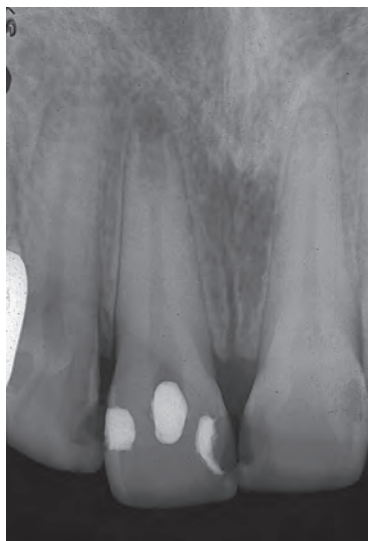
Apical inflammatory resorption has destroyed the “apical stop,” so periapical surgery and a root-end filling is recommended to complete treatment. Chronic inflammatory tissue is also removed.
